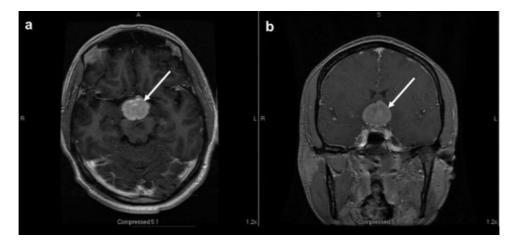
Preoperative (A) axial and (B) coronal T1-weighted cranial magnetic resonance imaging with contrast, revealing a 3-cm suprasellar mass with surrounding edema (solid arrows).
